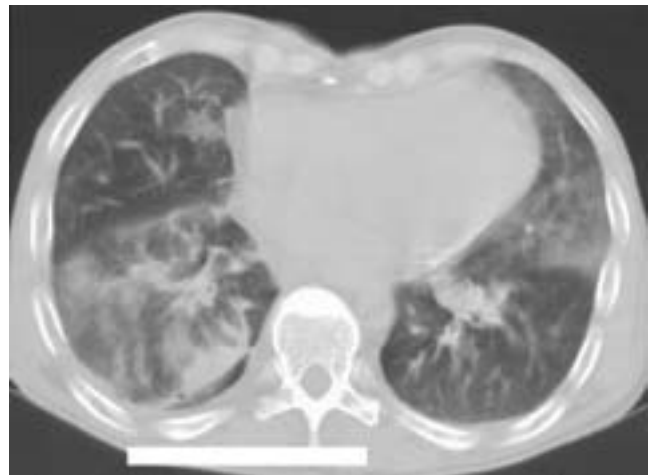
Basal chest CT scans displayed bilateral, diffuse areas of ground-glass attenuation, with a basal predominance.
